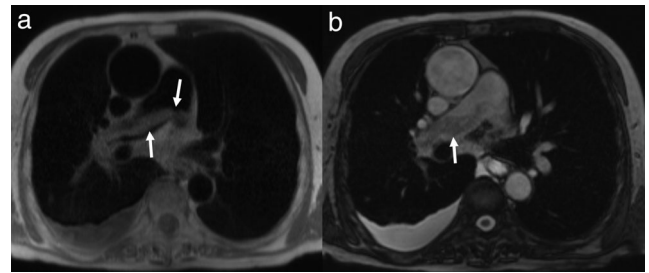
Black-blood MRI of incidental saddle pulmonary embolism in a 65-year-old man admitted with shortness of breath and congestive heart failure. Transaxial black-blood single-shot FSE MR image (a) demonstrates a linear hyperintensity straddling the left and right pulmonary artery (arrows), consistent with saddle pulmonary embolism. Flowing blood in the pulmonary artery is hypointense on black-blood MR images, owing to the double-inversion technique. The pulmonary embolism is more difficult to appreciate on corresponding transaxial bSSFP single-shot MR image (b, arrow) due to the more similar T_2/T_1 ratio between the thrombus and surrounding blood pool.
